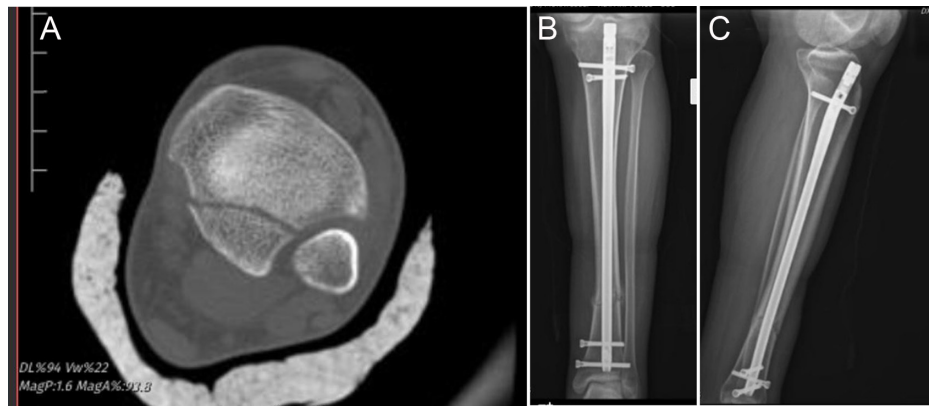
A-C. Case without posterior malleolar fixation. (A) Computed tomography image, (B) anterior posterior radiography, and (C) lateral radiography.
